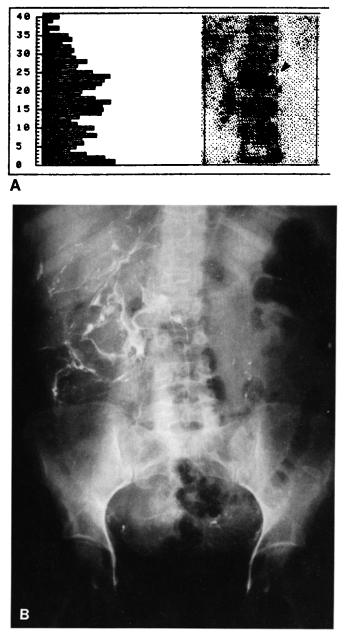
A, DPA of 39-yr-old female, exhibiting free barium in peritoneal cavity; B, corresponding radiograph of the patient.
